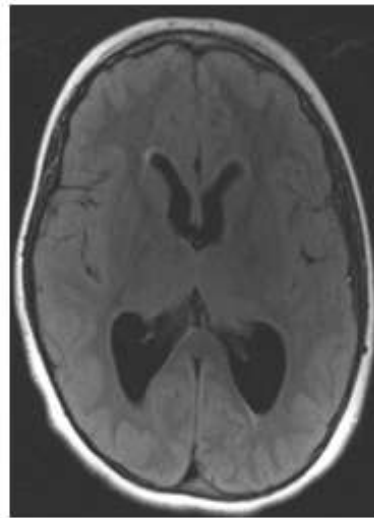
Axial MRI of Typically Developing Child (1) and 10-yr old female ETV Patient : Patient C (2, 3)
